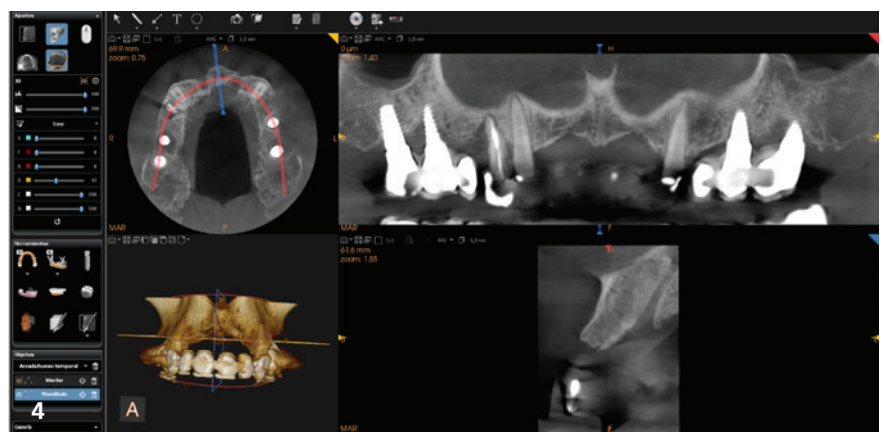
CBCT of the initial situation. – Fig. 5: Detailed view of the maxillary arch.
